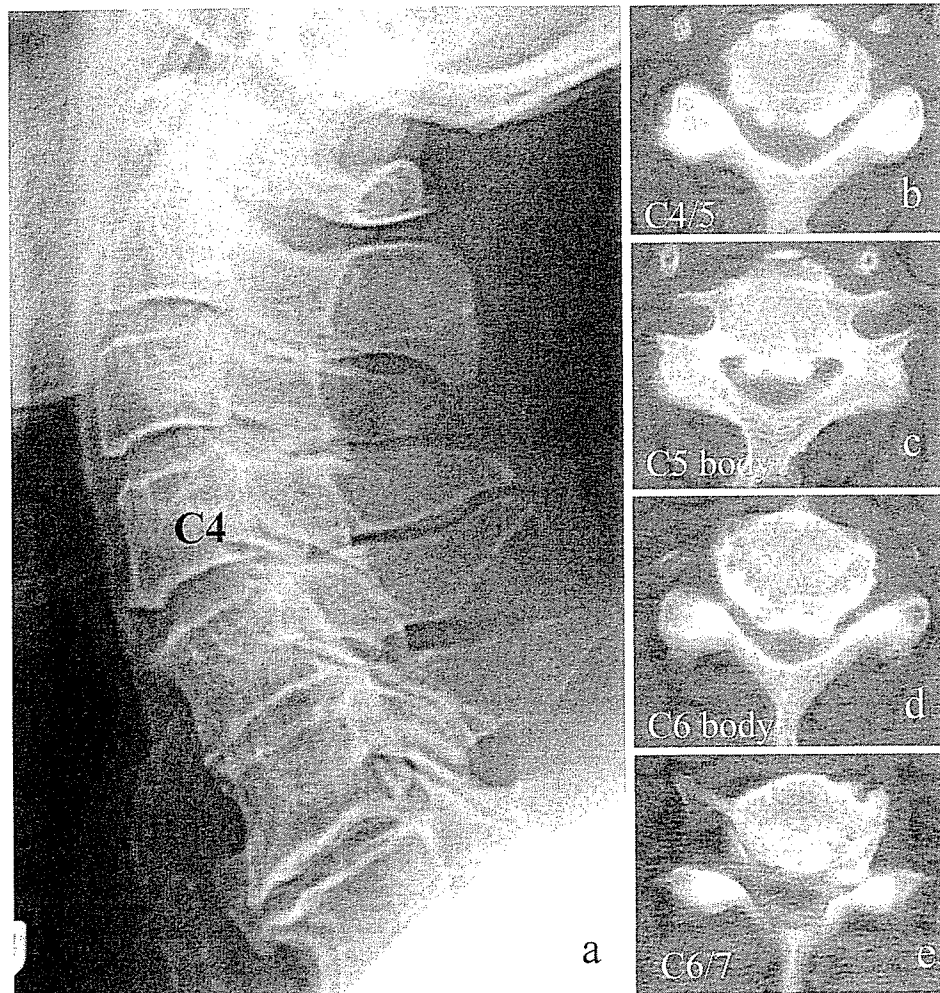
Continuous-type OPLL in a 66-year-old man. a Radiograph shows OPLL from C4 to C6-C7. The OPLL can be detected more easily using computed tomography (CT). CT shows
